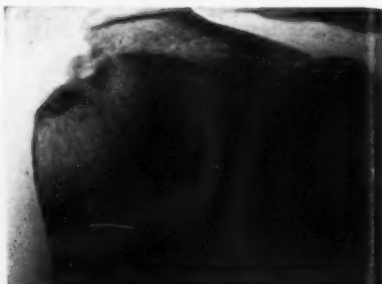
X-ray showing reduced density of calcium deposits, eight weeks after treatment.
